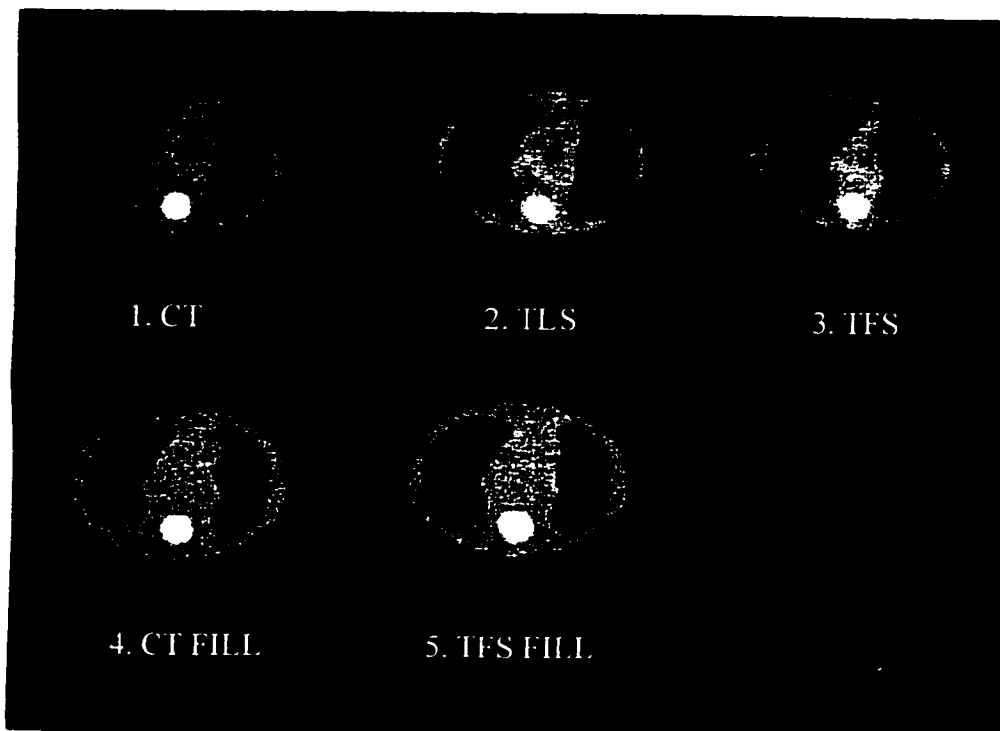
Transverse slice of registered attenuation maps: 1. CT, 2. TLS, 3. TFS , 4. CT FILL, 5. TFS FILL. The spine insert can be seen on all attenuation maps.
